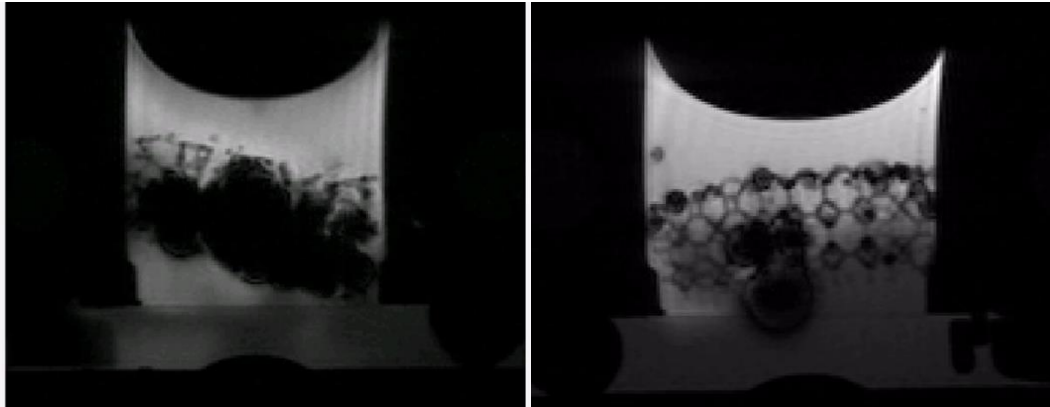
Voronoi (left) and IsoTruss (right) MRI scans.
